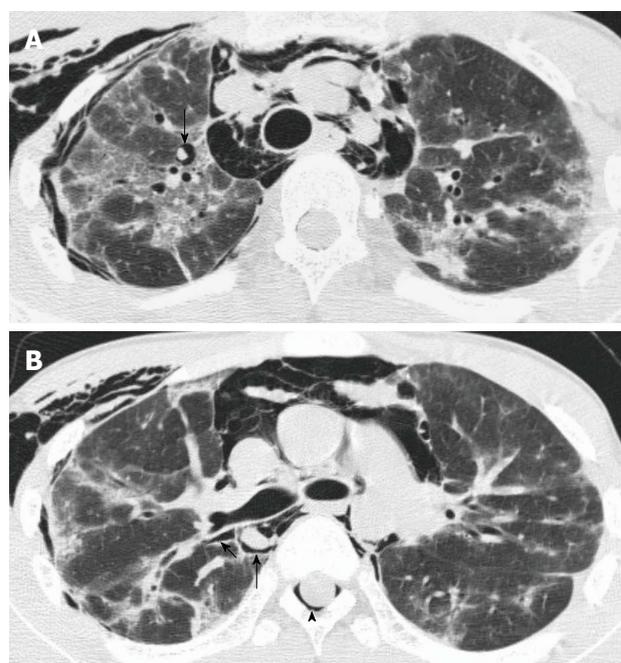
A 15-year-old girl with cryptogenic organizing pneumonia associated with graft-vs-host disease. Multidetector-row computed tomography scan demonstrates air collection along the perivascular connective tissue, the Macklin effect (arrows) in the peripheral area (A) and in the perihilar area (B), and massive pneumomediastinum. This patient also has spinal pneumorrhachis (arrowhead). Reprinted from ref. [5].
